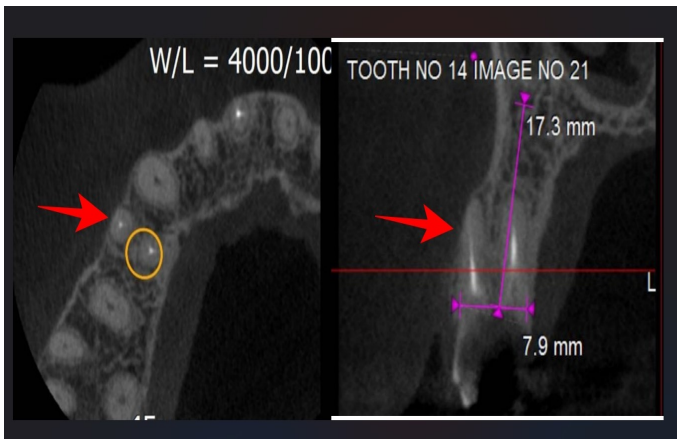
b. Pre operative Cone Beam Computed Tomography shows very thin buccal cortical plate in both axial and coronal planes
